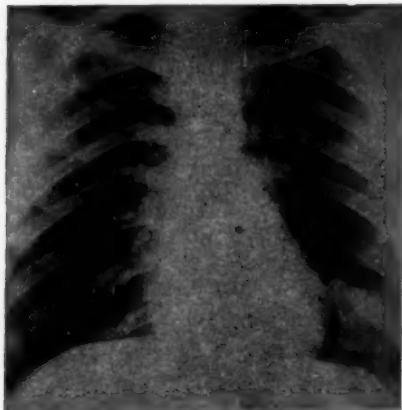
Antero-posterior radiograph of the chest showing the shadow in the lower lobe of the left lung. Taken in March, 1947.
